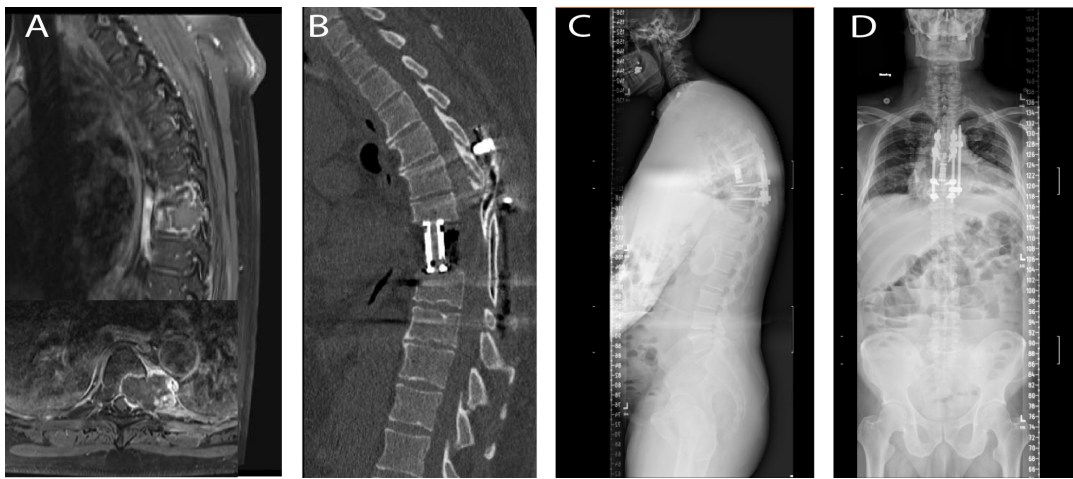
Fifty-two-year old man who underwent a T7 corpectomy with en bloc resection of a grade 2 chondrosarcoma and T5–T9 posterior fusion. This is an example of a case in which a custom implant would have been advantageous given the irregular margins of the tumor resection cavity. (A) Preoperative T1-post gadolinium magnetic resonance imaging revealed a 1.4 cm bony destructive mass within the T7 vertebral body and left pedicle with expansile component to the left paravertebral space and also left epidural component abutting the thoracic cord without cord compression (inset). (B) Postoperative computed tomography scan demonstrating an expandable titanium cage flush to the endplates of T6 and T8. (C) and (D) Postoperative stitched standing scoliosis films demonstrating anterior and posterior instrumentation.
